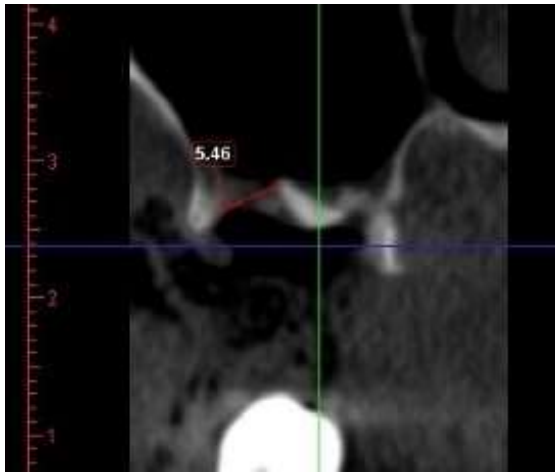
Postoperative cone-beam computed tomography image of the OAC.
